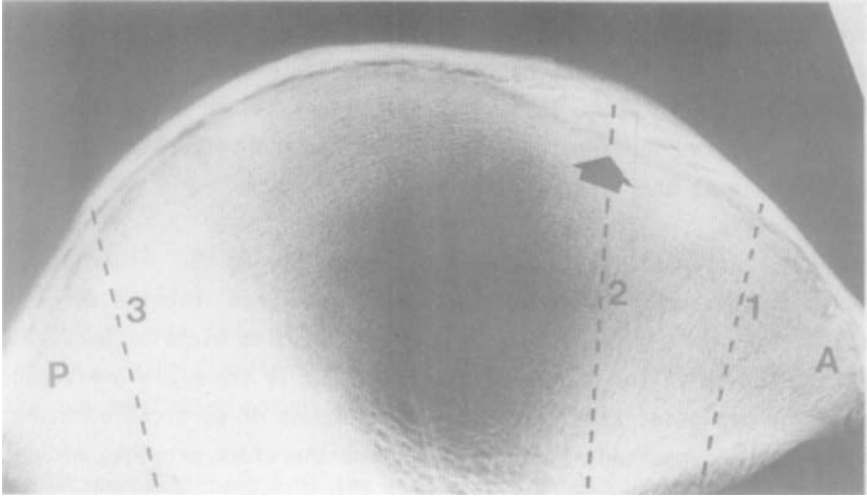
A lateral radiograph of an iliac crest removed at autopsy from a seventeen year old male who died by accident. The anterior and posterior superior iliac spines are marked 'A' and 'P', respectively. The tubercle of the crest is the thickest part of the crest (arrow). Note that the iliac apophysis has not yet fused with the underlying crest. Note also the strong anterior and posterior columns of bone within the crests separating a large deficiency of bone in the middle of the iliac fossa.
